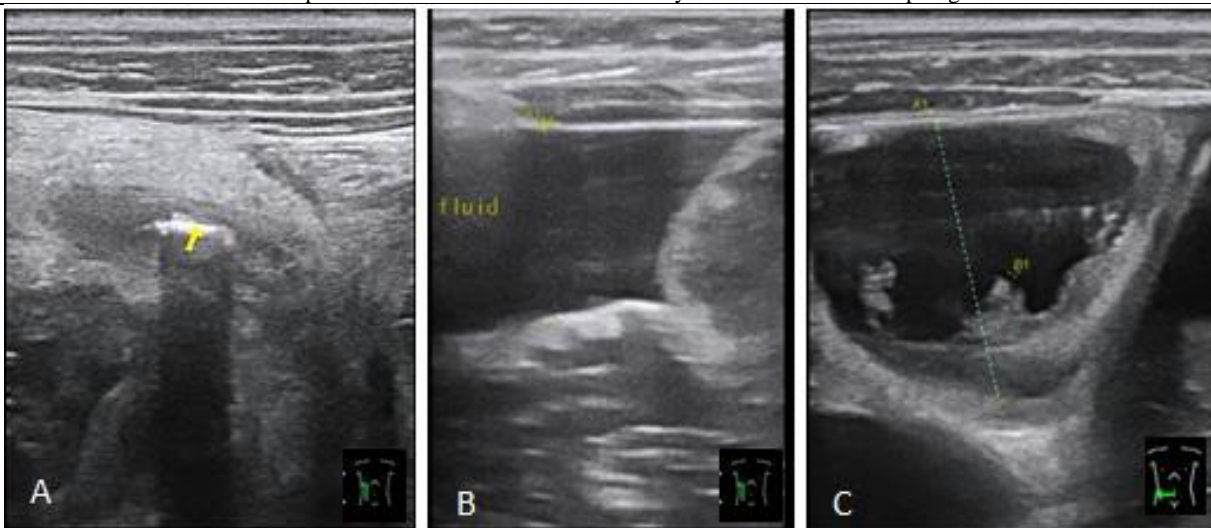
Ultrasound image of a 10 year old. A show an appendix with imperceptible walls and an echogenic linear structure within (appendicolith). B Longitudinal US in the RIF show free peritoneal fluid with echoes. C transverse US in the RIF show dilated loops of bowel with no peristalsis.
